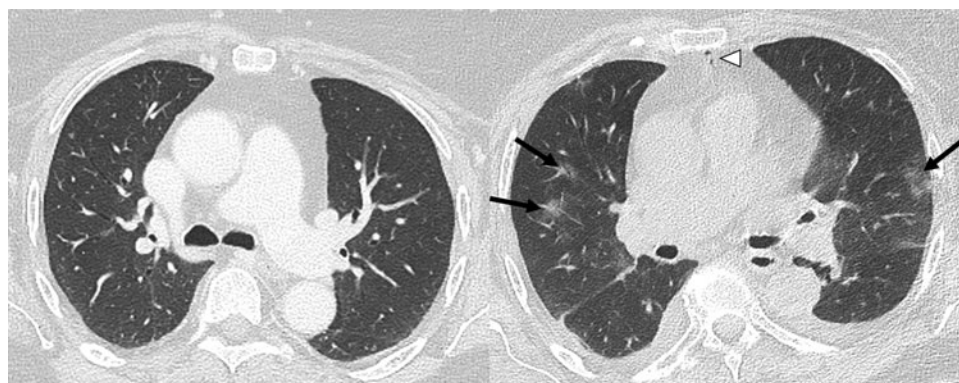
Baseline (left) and post-operative (right) chest computed tomography (CT) of patient 7, showing the appearance of diffuse round ground-glass opacities (arrows) and minimal post-operative pneumomediastinum (arrowhead).
